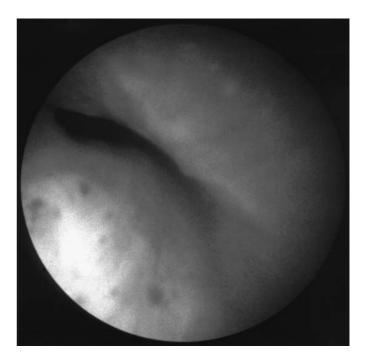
Postpneumonectomy syndrome after a right pneumonectomy with obstruction of the left lower lobe bronchus alone, in a 39-year-old woman who had a right pneumonectomy 1 year before because of abscess, pneumonia, and hemoptysis in a congenitally cystic lung with ectatic bronchi and vascular anomalies. Six months later, she recognized progressive dyspnea, which became incapacitating. A, Computed tomography scan shows near complete obstruction of the left lower lobe bronchus (arrow) between the pulmonary artery and aorta. The upper lobe bronchus was rotated but open. Note the reduced volume of the right hemithorax related to the relatively nonfunctional right lung, which had resided there. Repositioning and insertion of saline-filled prostheses produced complete relief. Pre- (B) and postoperative (C) bronchoscopies. The lower lobe bronchus is a mere slit preoperatively (arrows). Both primary divisions of the upper lobe are seen. Both lobar orifices are widely patent postoperatively.
